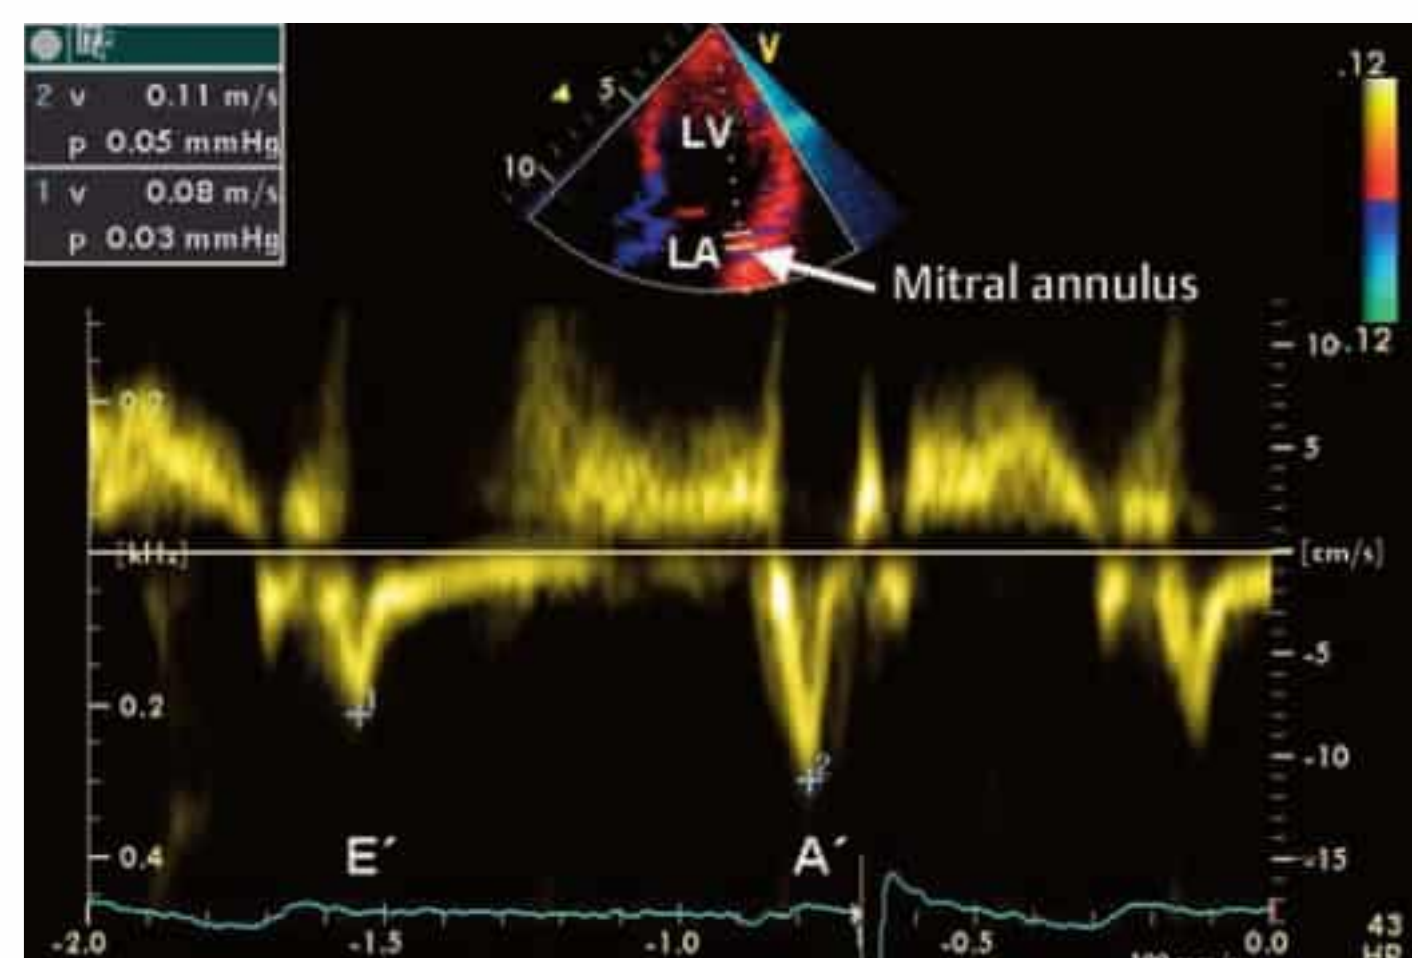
Tissue Doppler of the lateral mitral annulus velocities in the 4-chamber view with a high A' wave and low E' wave.
